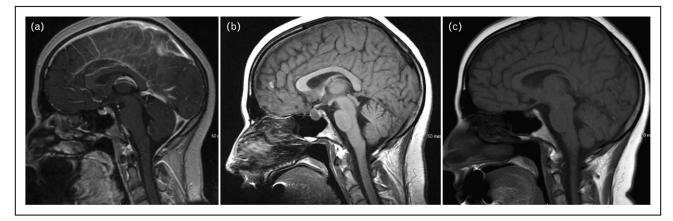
(a) MRI with gadolinium contrast of sella turcica sagittal view before ipilimumab demonstrating normal appearance of pituitary gland with concave upper margin. (b) MRI with gadolinium contrast of sella turcica sagittal view at the time of presentation with hypophysitis demonstrating pituitary gland enlargement with convex upper margin and optic chiasm impingement. (c) MRI with gadolinium contrast of sella turcica sagittal view at 3-month follow-up demonstrating a small pituitary gland with an almost empty sella appearance.
